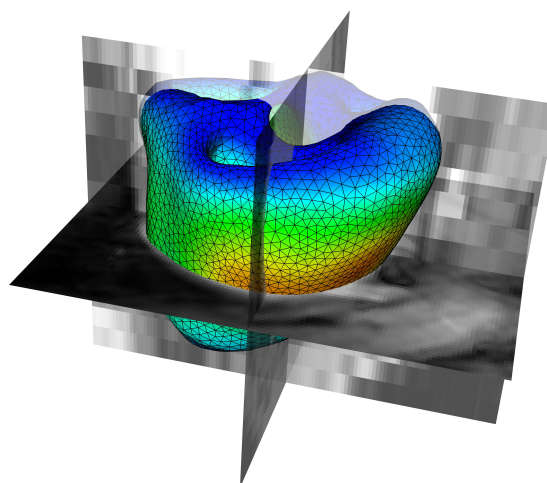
Heart model immersed in MR image data
